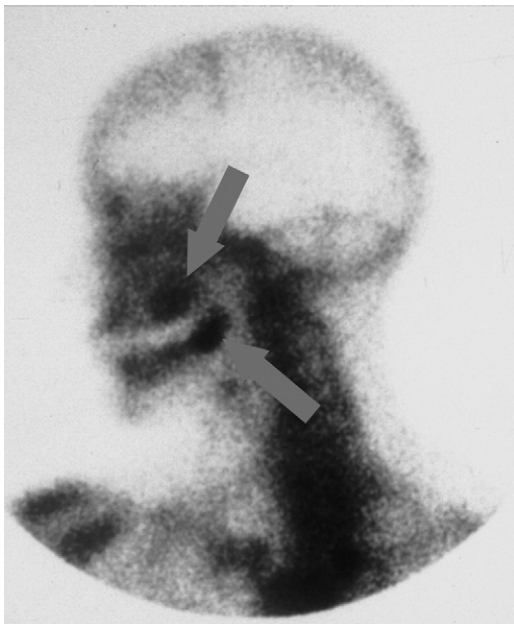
Technetium-99 MDP scintigraphy scan of 2 alveolar regions of painful ischemic bone damage in a patient with neuralgia-inducing cavitation osteonecrosis of the jaws, showing intense uptake in both damaged areas (arrows).
